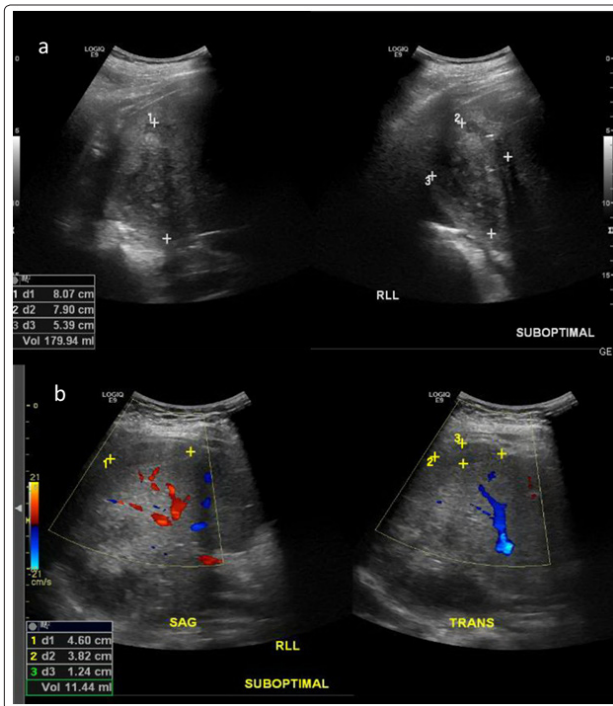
US after 17days of second CT demonstrates interval decrease in liver abscess size as well as improvement in sub diaphragmatic collection.
